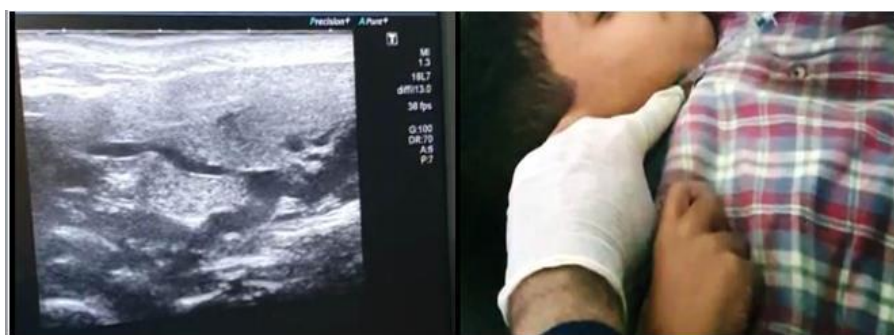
Ultrasound-guided injection into the submandibular salivary gland (case 3)
